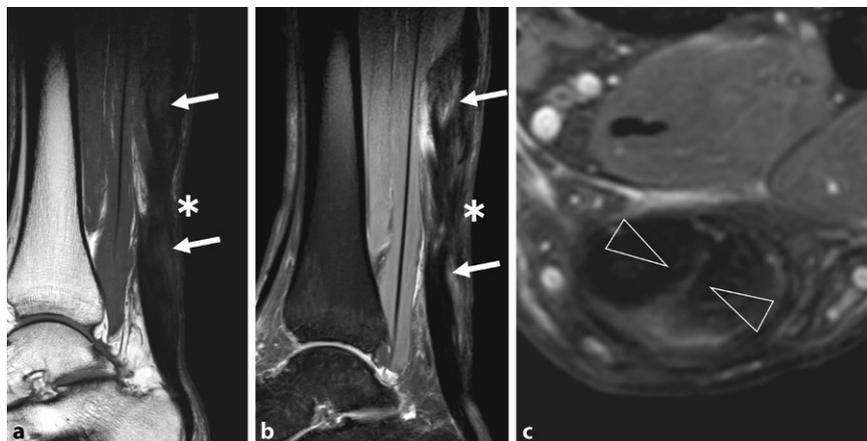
▲ At the 3-month follow-up, on MRI in T1-weighted (a) and STIR (b) sequences the tendon is still heterogeneous and shows areas of intratendinous signal increase (arrows) with poor delineation of the former rupture area (star). The axial plane with STIR sequences (c) is best for identifying the portions of the attached tendon stumps and identifying the remaining interface (arrowheads)
